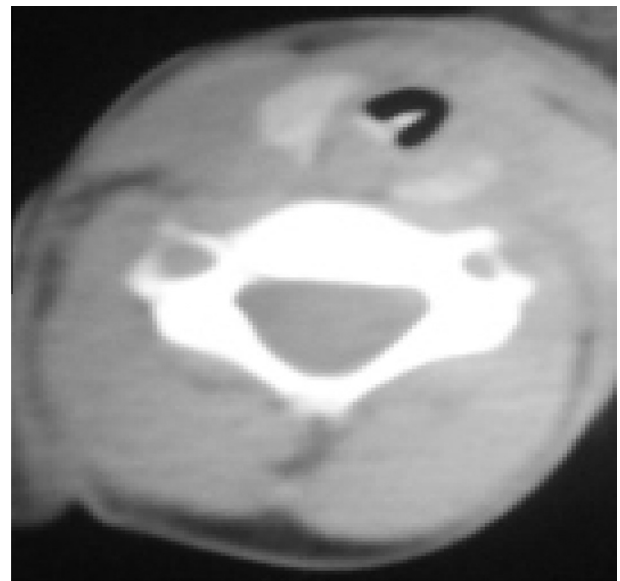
CT scan of the neck (axial view) showing FB in upper part of the trachea.
